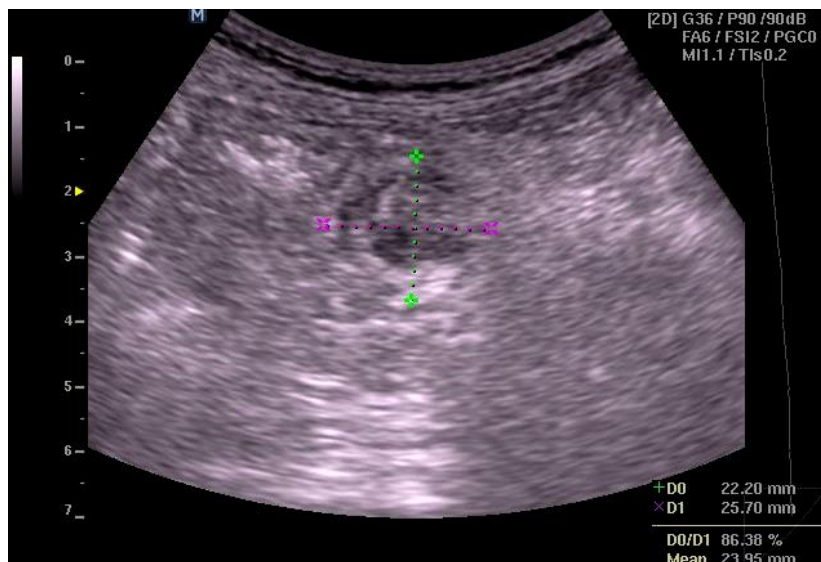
Patient B., 44 years (comparative group). Sonography of postoperative abscess in zone of colonic anastomosis
